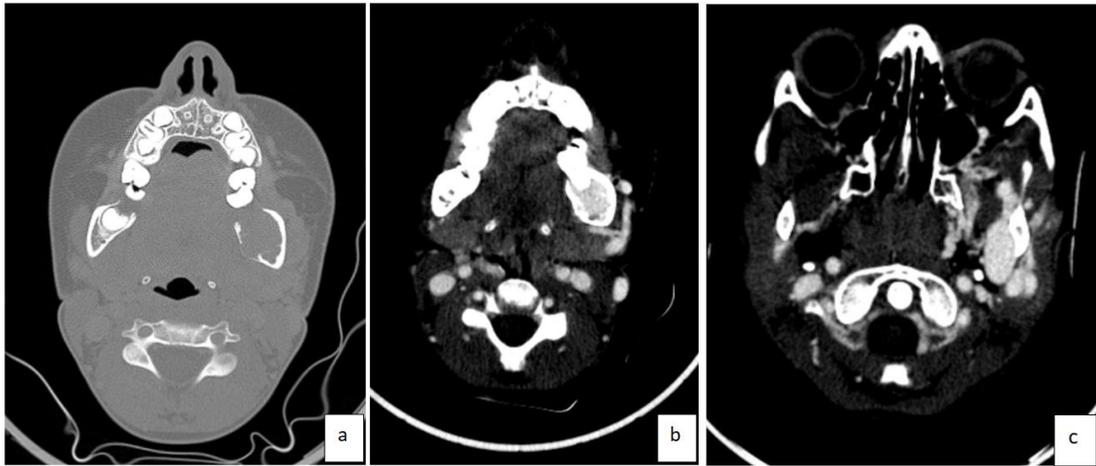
Axial CT scan in the bone window showing an osteolytic lesion (a) with localized cortical disruption in the ascending ramus of the left mandible, in which an intensely enhanced vascular structure can be seen after PDC injection (b), (c).
